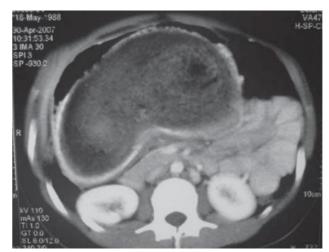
Axial computed tomography scan at the gastric body level demonstrating a "whorled mass" occupying its entire lumen.
